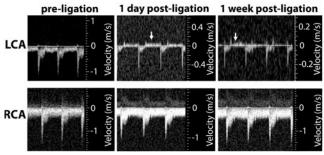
The ultrasound images show flow velocity profiles and reveal that partial ligation induces flow reversal (indicated by arrows) in LCA during diastole. Flow in RCA remains unchanged after ligation.
